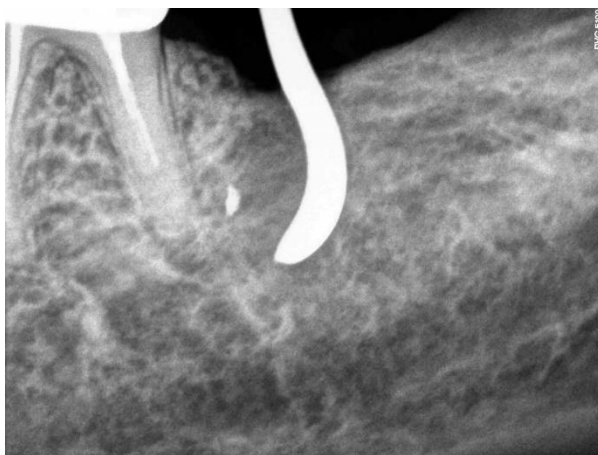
Dental radiograph showing curette positioned for the removal of amalgam particle in the region of missing 37.
